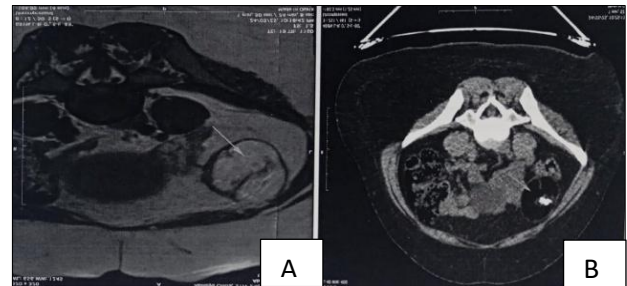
(A and B): MRI pelvis.
